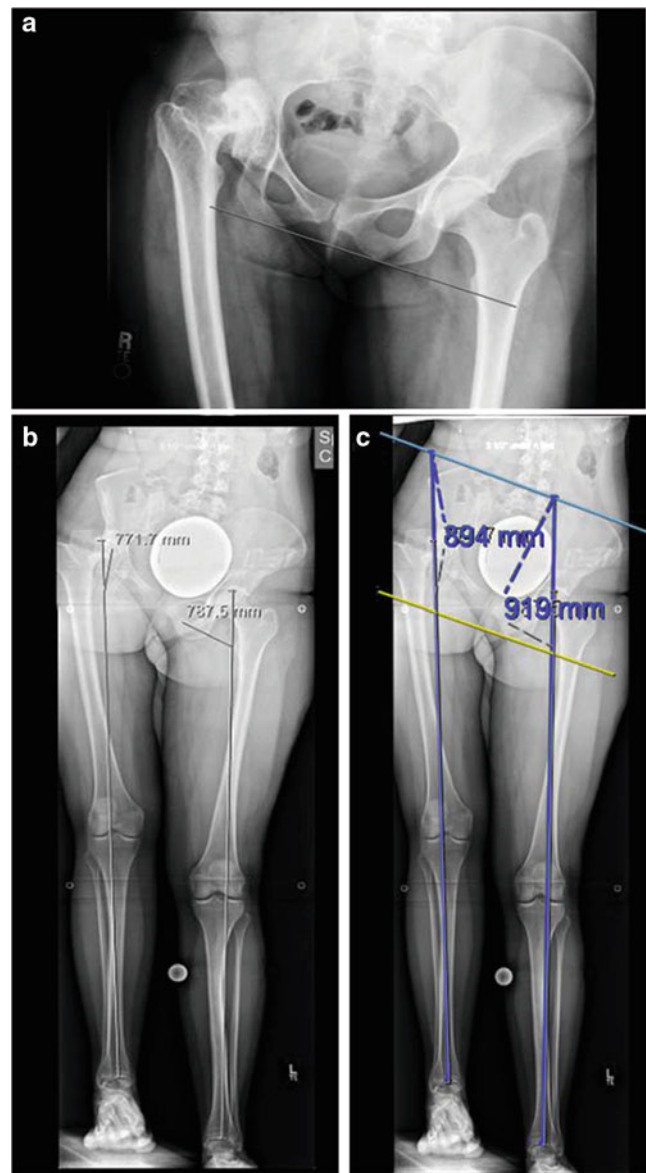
Preoperative (a) anteroposterior (AP) view of the pelvis demonstrating end-stage arthrosis of the right hip with a deformed, superiorly subluxated femoral head and a dysplastic acetabulum. (b, c) 51-inch-long erect radiographs of the hip to the ankle demonstrate a true LLD of 25 mm, due to bony deformity and soft-tissue contractures around the hip. The patient felt comfortable with a 90-mm block under her right lower extremity. True LLD = 25 mm; perceived LLD = 90 mm. Apparent LLD from POACH was 65 mm in this case
